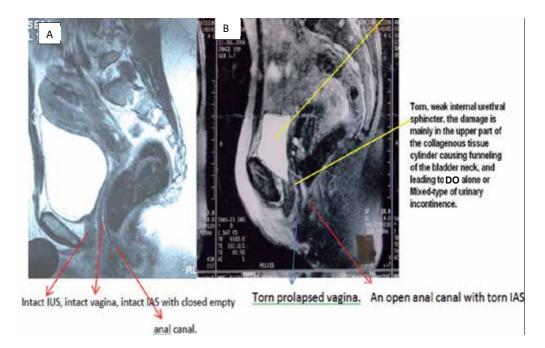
MRI images of a patient who suffers from SUI and FI. The IUS is torn especially in its upper part with funneling of the bladder neck, and torn IAS with an open anal canal.
